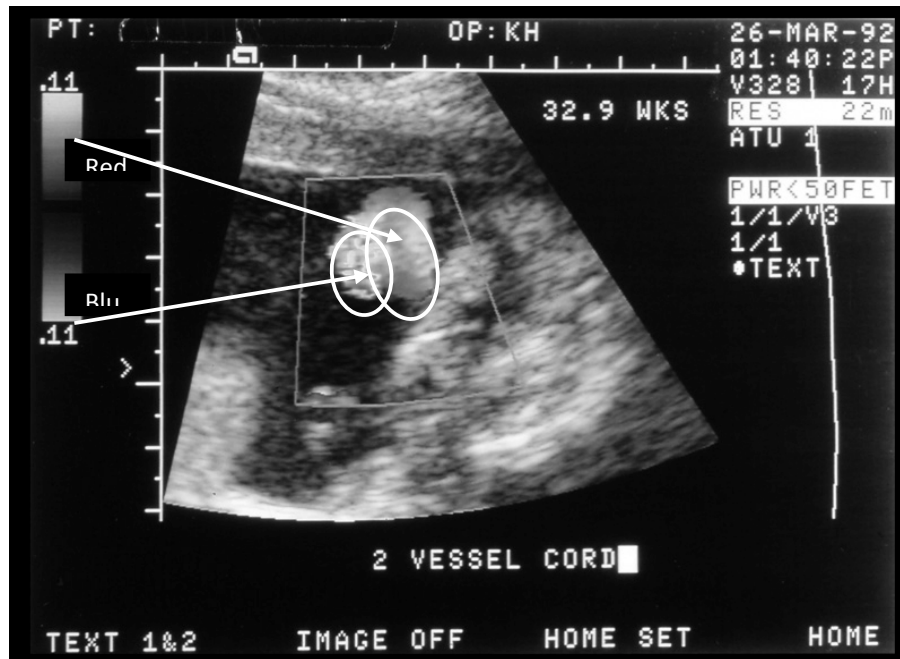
Two vessel cord. A third trimester black & white version of a color Doppler image of the cross-sectional view of an umbilical cord (personal communication, Alan Donnenfeld, MD). A normal umbilical cord has 3 vessels (2 arteries and a vein). This image shows only two vessels (indicated by the white ovals), one would be colored red and the other blue.
